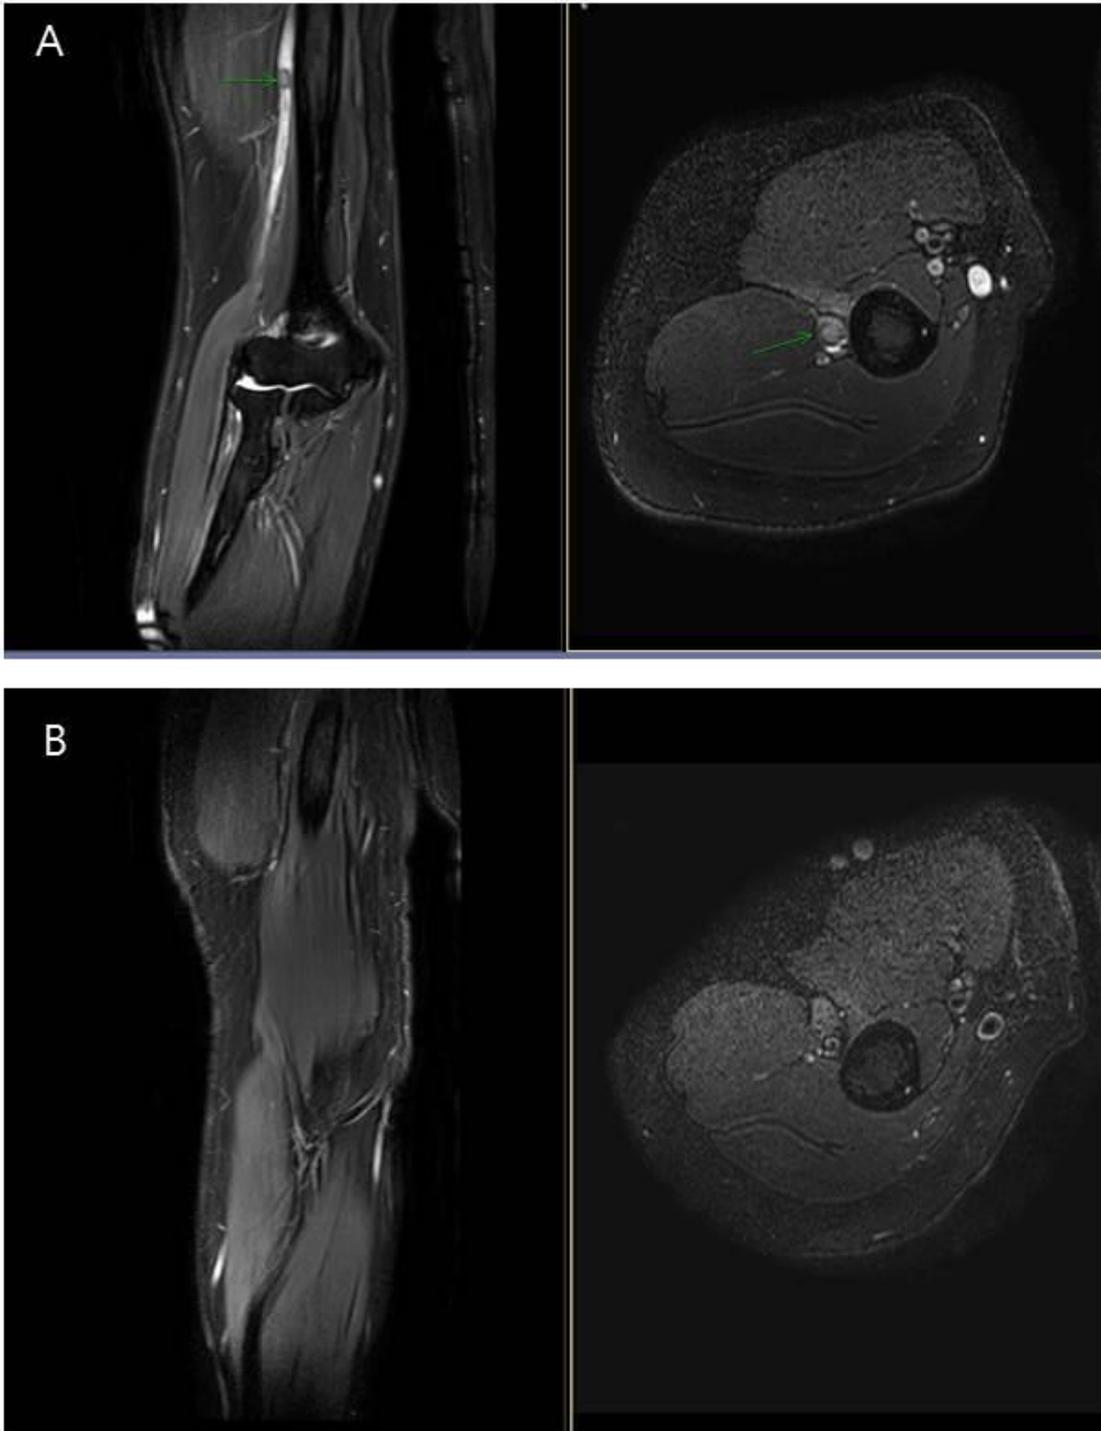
Initial Fat Suppressed Contrast-Enhanced T2-Weighted MRI image shows intraperineural nodule at midshaft level of right humerus with high signal intensity of radial nerve.
